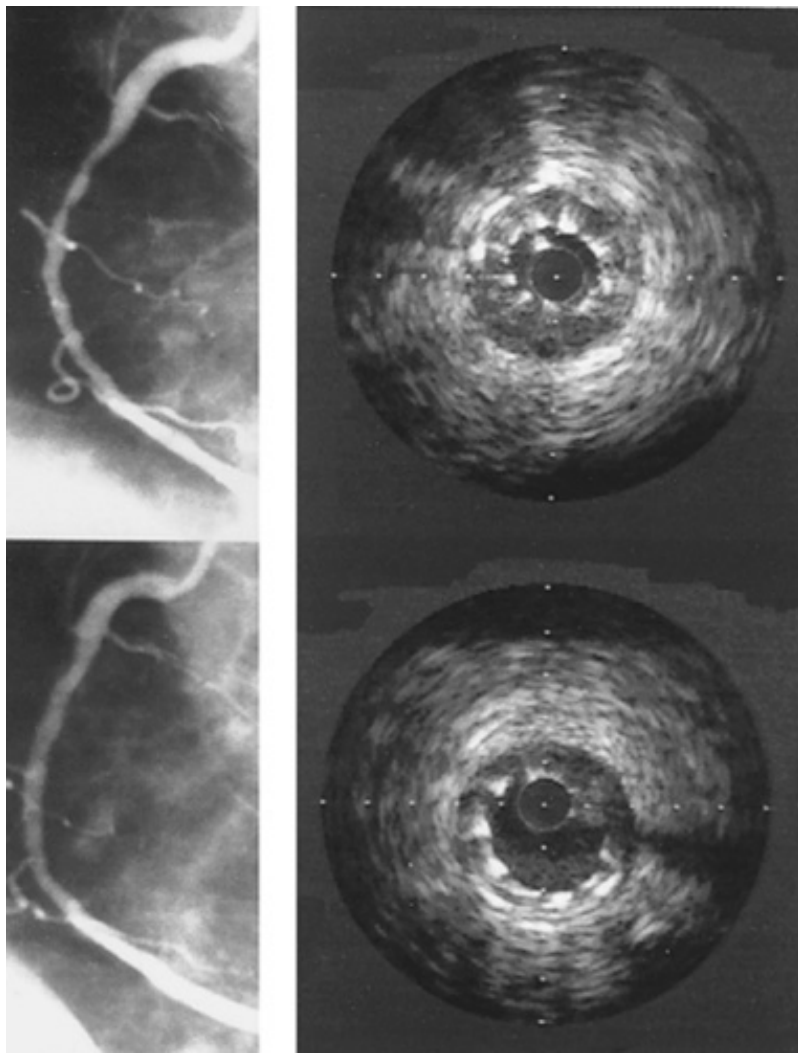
A 74-year-old woman developed early recurrence of angina after balloon angioplasty of the right coronary artery. Coronary arteriography revealed a severe, long stenosis of the right coronary artery (*top left*). Stenting was advised, and a Wallstent was deployed and dilated with a 3.5-mm balloon to 15 atm with an excellent angiographic result (*bottom left*). IVUS, however, showed that the distal end of the stent had been missed with the balloon and was poorly expanded (*top right*). This area was "redilated" to 16 atm with no change in the angiogram but much better stent expansion and wall apposition by ultrasound (*bottom right*). Following repeat dilation, the lumen cross-sectional area increased from 4.2 to 6.4 mm².
